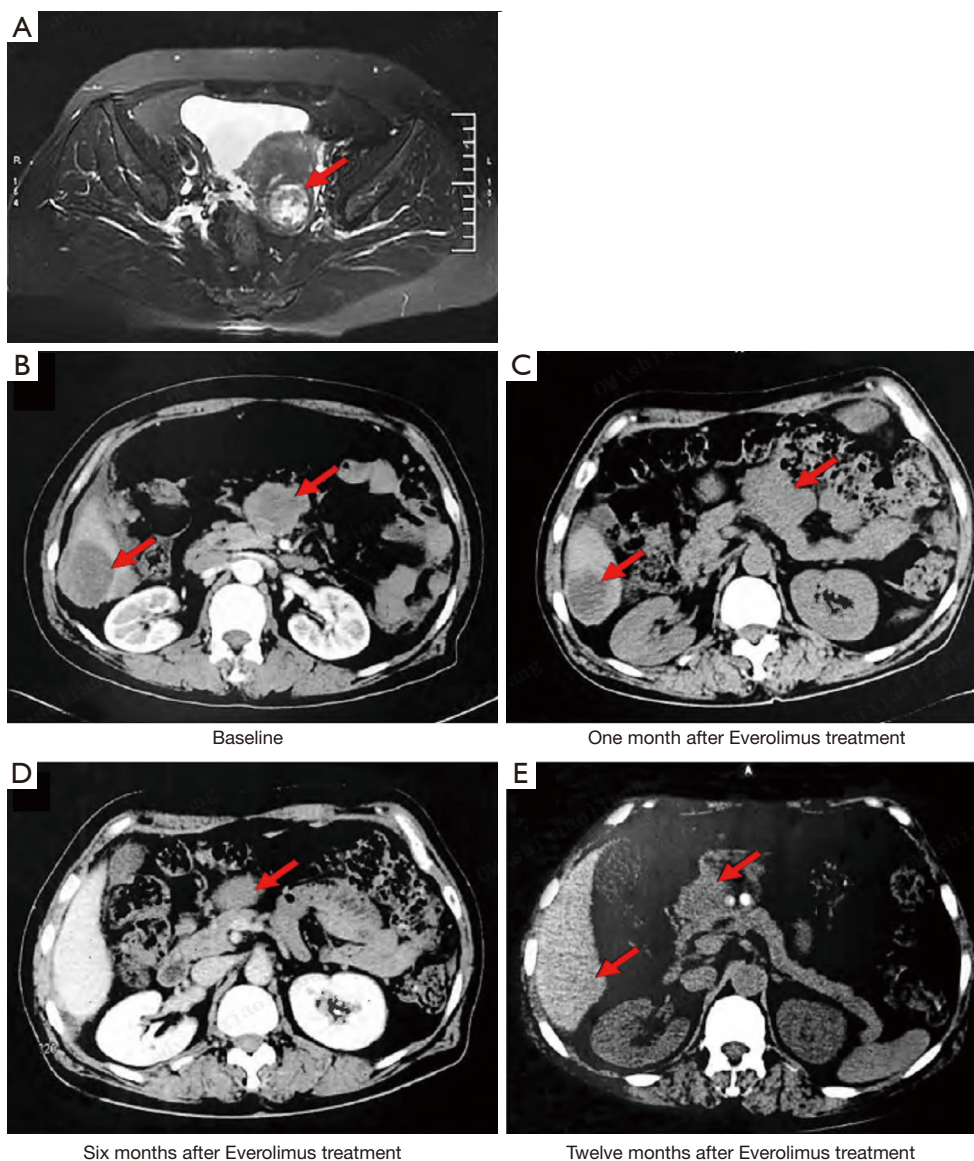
Image evaluation of the patient. (A) MRI examination in December 2012. CT scans, (B) baseline; (C) the patient received everolimus treatment for 1 month; the patient received everolimus plus carboplatin treatment for 6 months (D), and 12 months (E). The red arrow indicates the location of the tumor. MRI, magnetic resonance imaging; CT, computed tomography.
